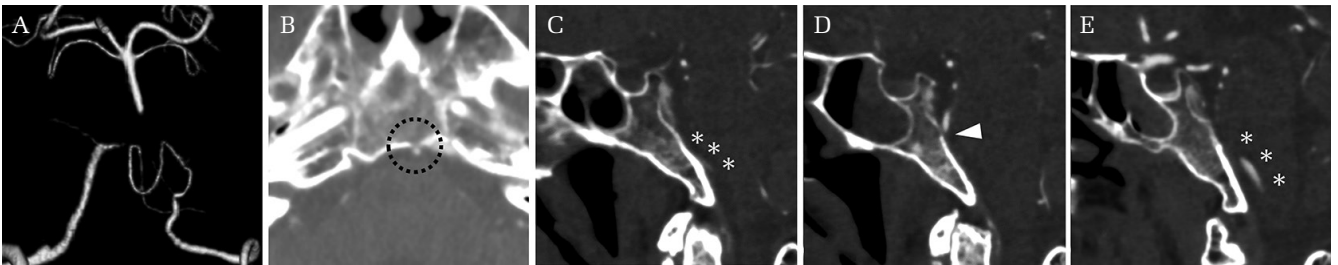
Computed tomography (CT) images of the head at admission showed occlusion of the basilar artery trunk. (A) Poor description of the left vertebral artery distal to the posterior inferior cerebellar artery (C), and the right vertebral artery proximal to the bifurcation (E). The lower half of the basilar artery trunk was entrapped in a minor hole in the middle part of the clivus (B, D).
